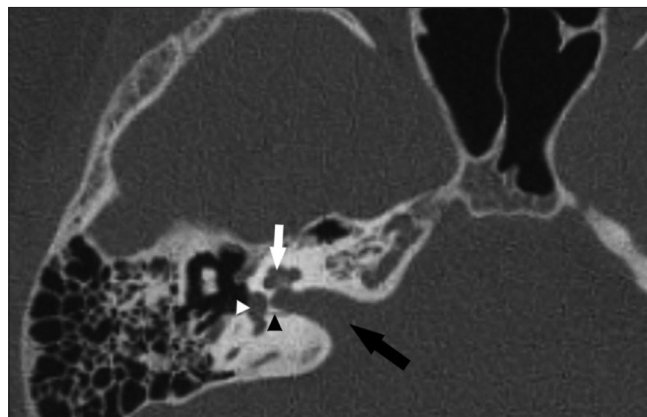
Axial computed tomography scan with bone window-weighting. Black arrow: Internal acoustic porus, black arrowhead: Singular canal, white arrow: Cochlea, white arrowhead: Vestibule
